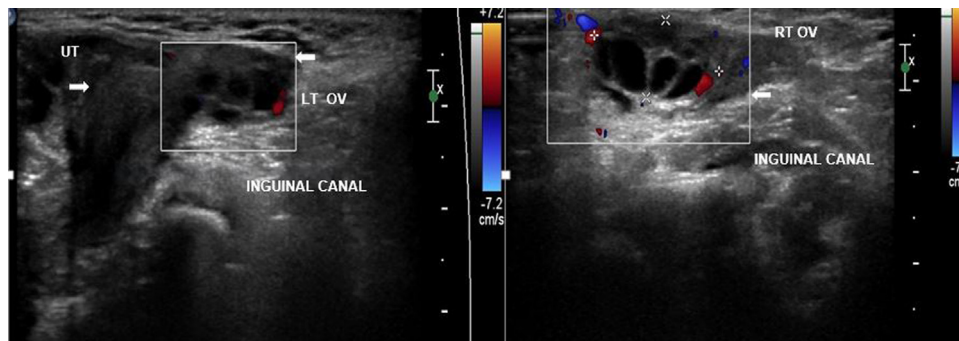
On color Doppler ultrasonography vascularity is seen in both ovaries.
